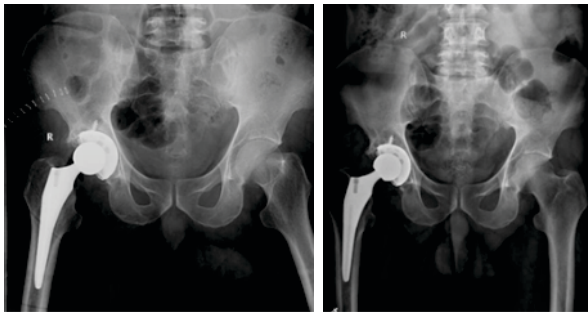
Pre- Operative Anteroposterior Radiography Of The Hip
